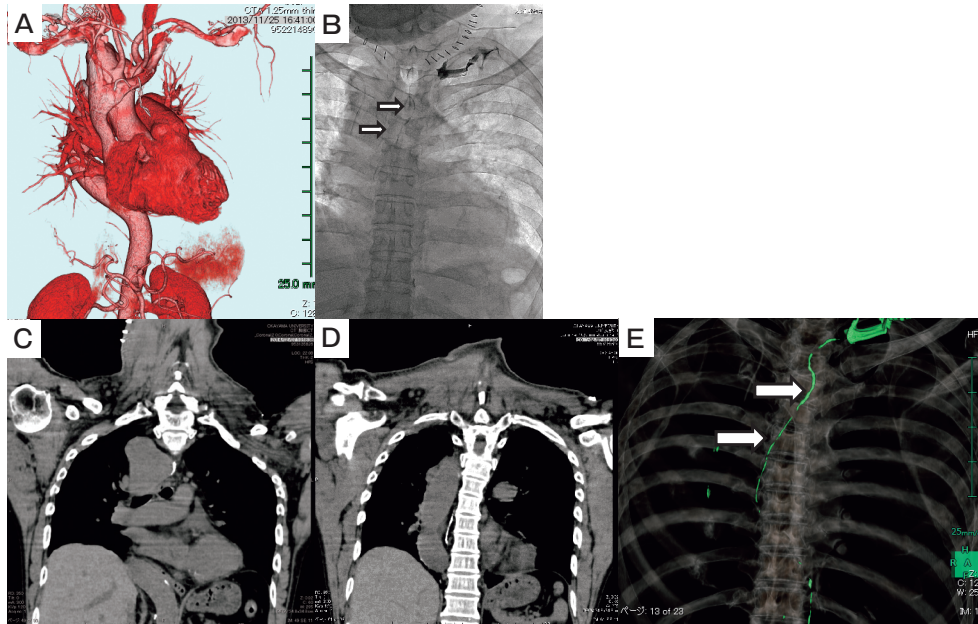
CT and Lymphangiography findings. (A) Three-dimensional CT angiography shows the right aortic arch and the aberrant left subclavian artery. (B) Lymphangiography shows the normal location of the thoracic duct and the chyle leak in the cervical region. (C, D) CT shows the normal location of the thoracic duct and the abnormal location of the aorta. (E) CT lymphangiography clearly shows the location of the thoracic duct.
